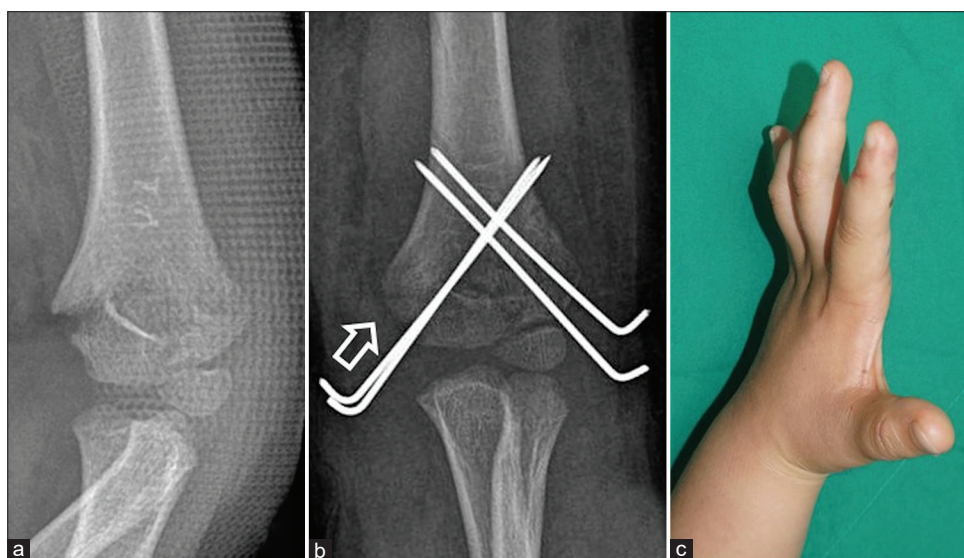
Pre-operative anteroposterior radiograph of a 4-year-old boy with displaced supracondylar humeral fracture (a). Cross-pinning achieved an acceptable reduction. However, the medial pin was started at the inaccurate area, which seems distal to the unossified medial epicondyle (arrow) (b). Ulnar claw hand occurred in this patient (c).
